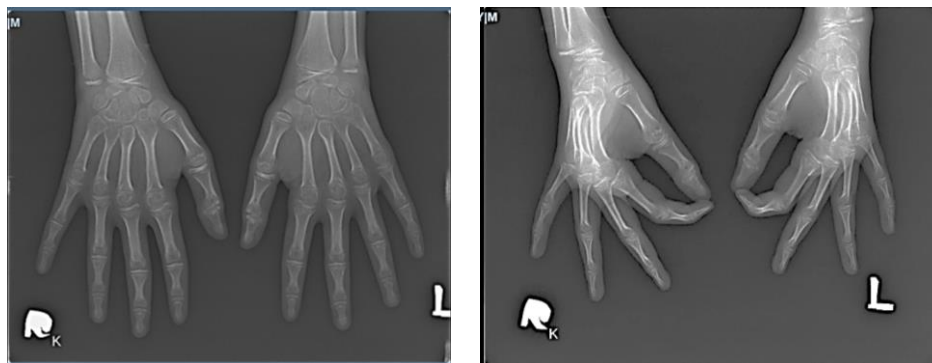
AP/lateral manus plain radiograph X-ray.
